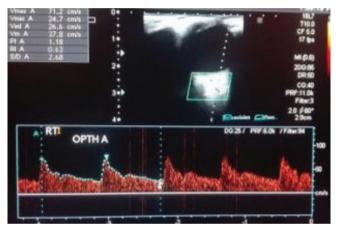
Ultrasound image of a preeclamptic female at 33 weeks of pregnancy representing low RI (0.63) of the ophthalmic artery
